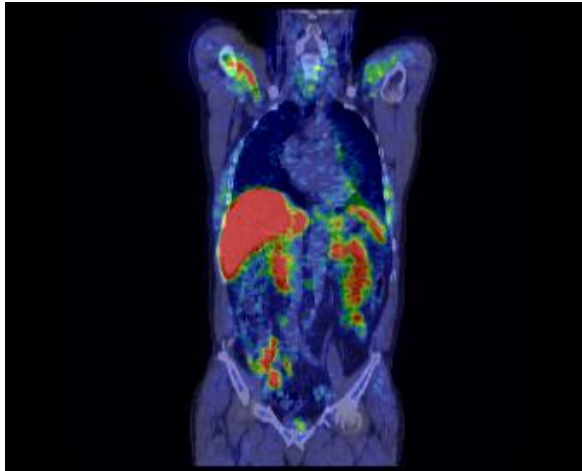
Coronal view of fused ^{11}C -choline PET/CT showing physiological distribution of the tracer. No pathological ^{11}C -choline uptake sites could be detected.
